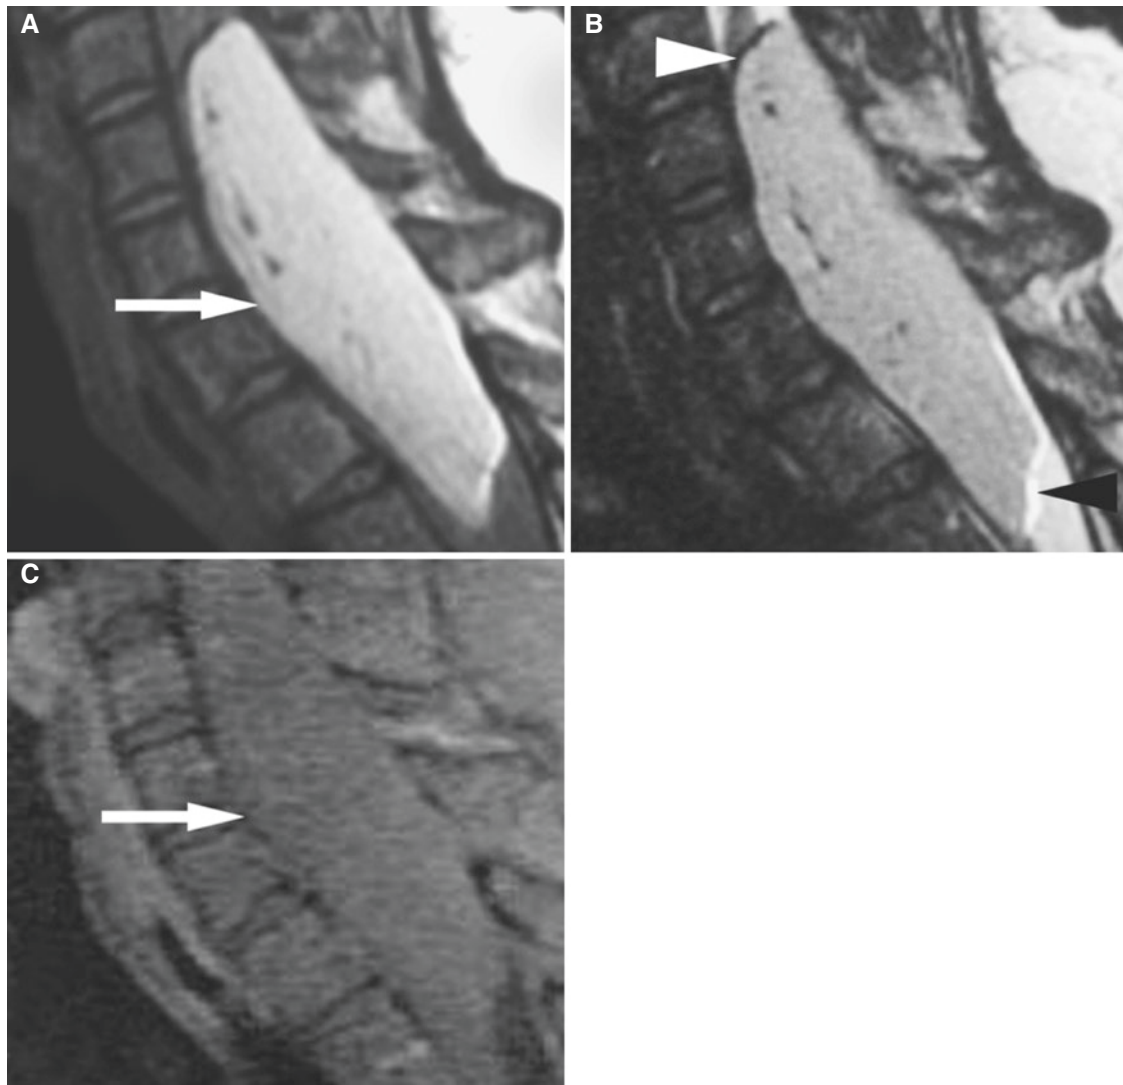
Extramedullary cervical lipoma with cord compression; patient had long history of cord compression symptoms. Surgery confirmed the location and fatty nature of the encapsulated tumor. (A) Sagittal proton density MRI shows a large intradural mass (*arrow*), secondarily widened canal to long-standing pressure tumor. (B) Sagittal
